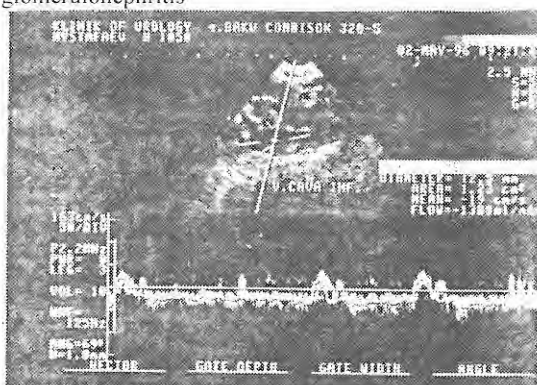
Duplex sonogram of the inferior vena cava in a patient with chronic pyelonephritis complicated by initial stage of chronic renal failure: the border between negative phases is eliminated
